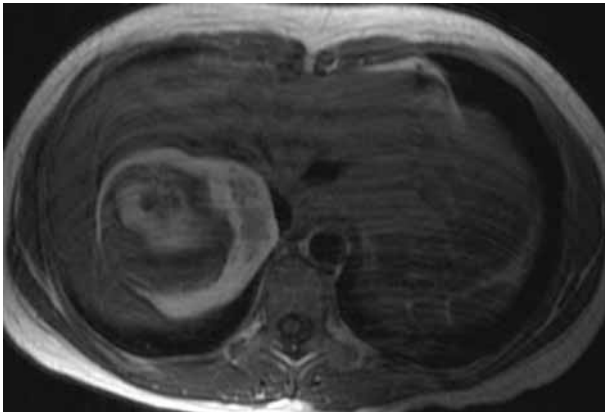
Axial T1-weighted MR image : the peripheral and the central areas demonstrated increased signal intensity, and the soft tissue component was isointense to hyperintense relatively to muscle. The calcification had low signal intensity.
